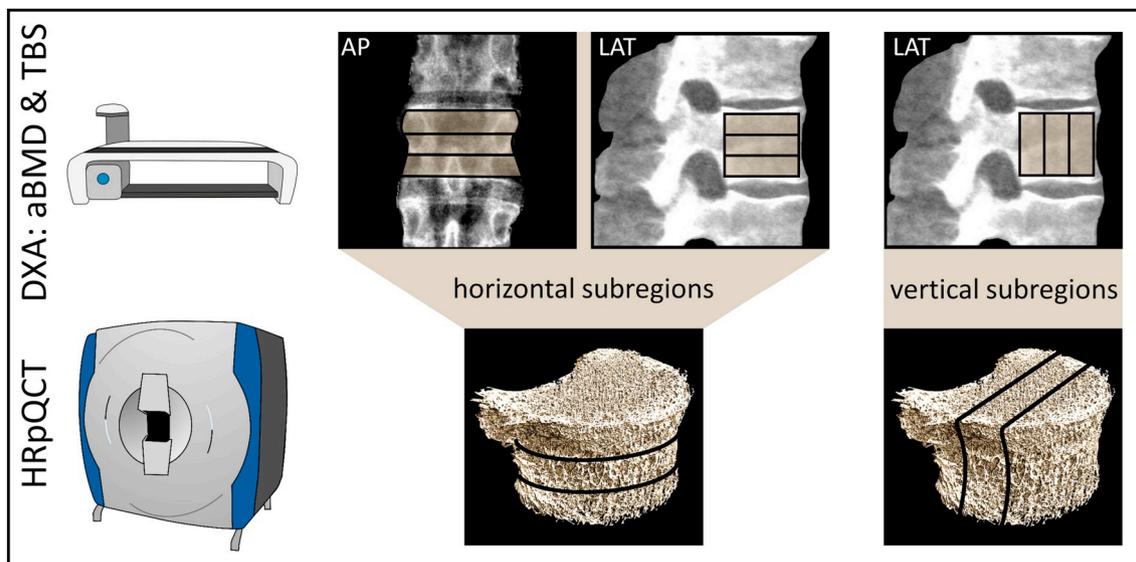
Methods for analysis of vertebral subregions: Subregional evaluation of 3D trabecular microstructure was performed based on HRpQCT scans and subregional evaluation of 2D parameters, aBMD and TBS, based on dual energy x-ray absorptiometry scans.
